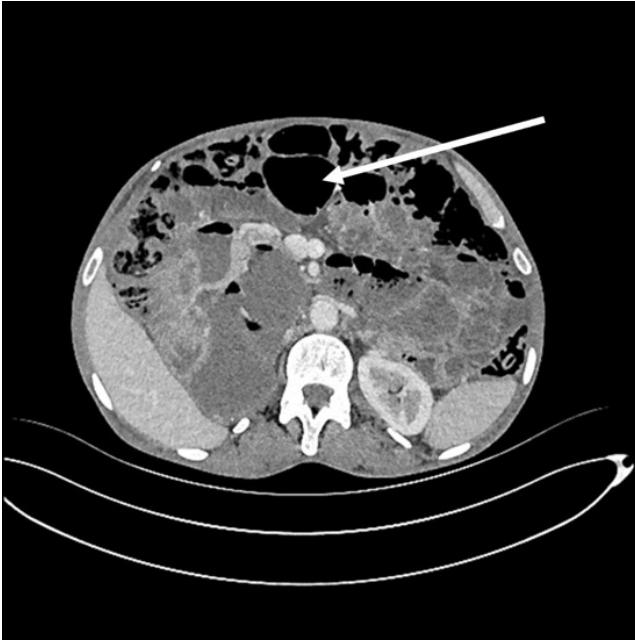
A section of abdominal computed tomography
